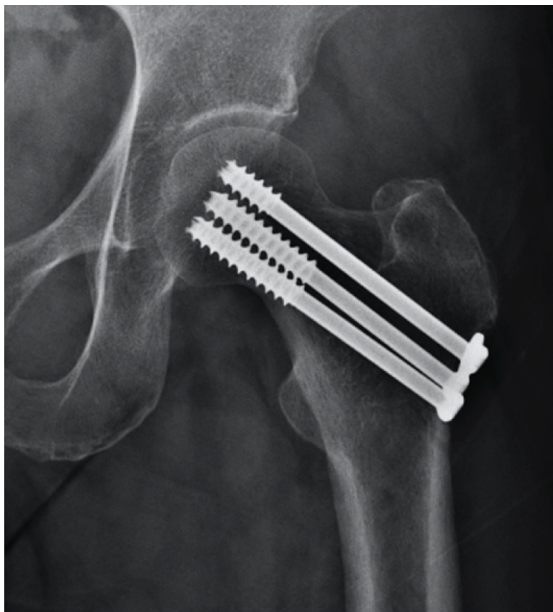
Union was observed radiographically 3 months after multiple cannulated screws fixation.
